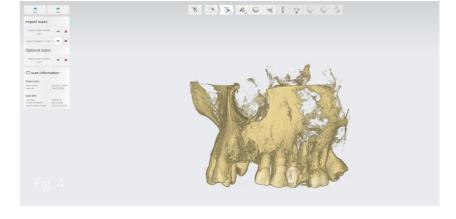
3D renderad CBCT volume.
